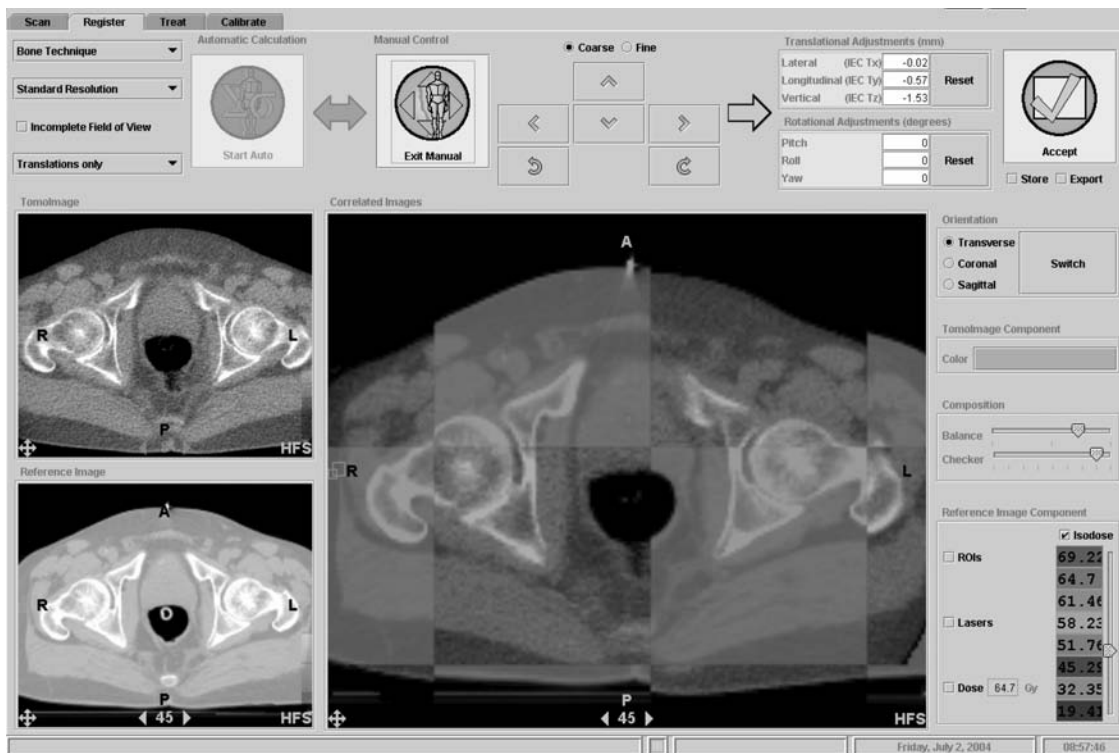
The registration window for a prostate patient. The gray squares are from the planning CT. The verification CT is shown in the upper left and the planning CT is in the lower left. The yellow squares in the large panel are from the tomotherapy verification CT. The rectal boundary and the fat pad surrounding the prostate are clearly aligned on these transverse images. Note that the skin boundary and the leg bones are not as well aligned as the prostate. Regions of interest and the dose distribution obtained from the planning system can be superimposed on the images, but these capabilities have been turned off in this presentation. The translational alignments suggested were 0.0 mm lateral, -0.6 mm longitudinal, and -1.5 mm vertical.
